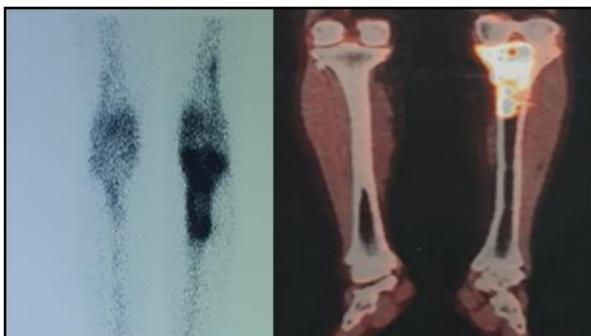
Skeletal scintigraphy and Pet scan
